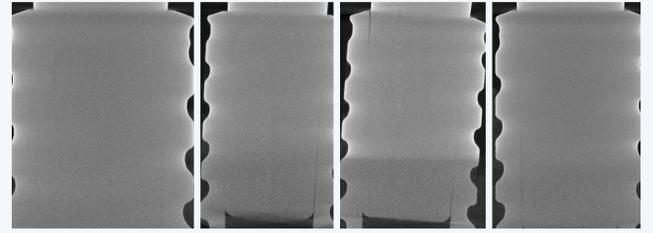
Small manufacturing defects are also clearly visible in X-Ray tomography.
